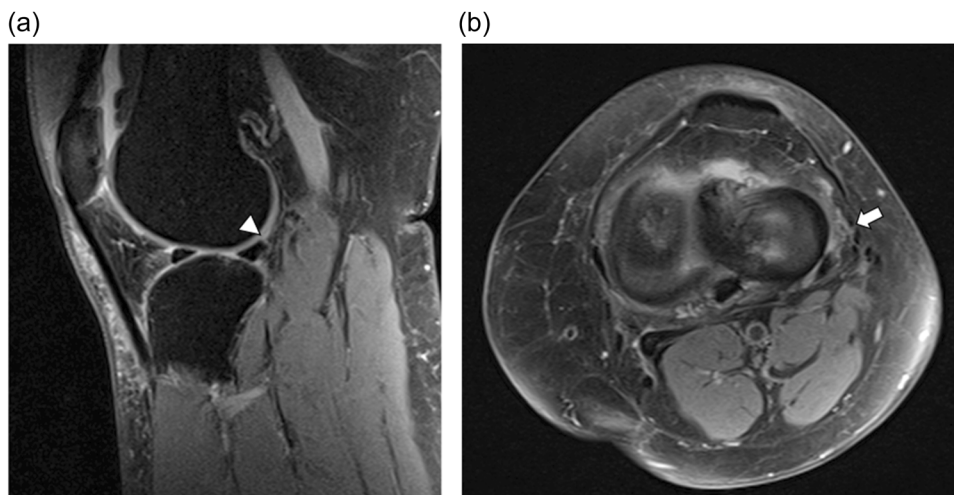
Sagittal (a) and axial (b) proton-density-weighted fat-saturated magnetic resonance images of a 45-year-old female patient with an associated RAMP type 1 lesion (white arrowhead in a) and complete anterolateral ligament lesion (white arrow in b).
